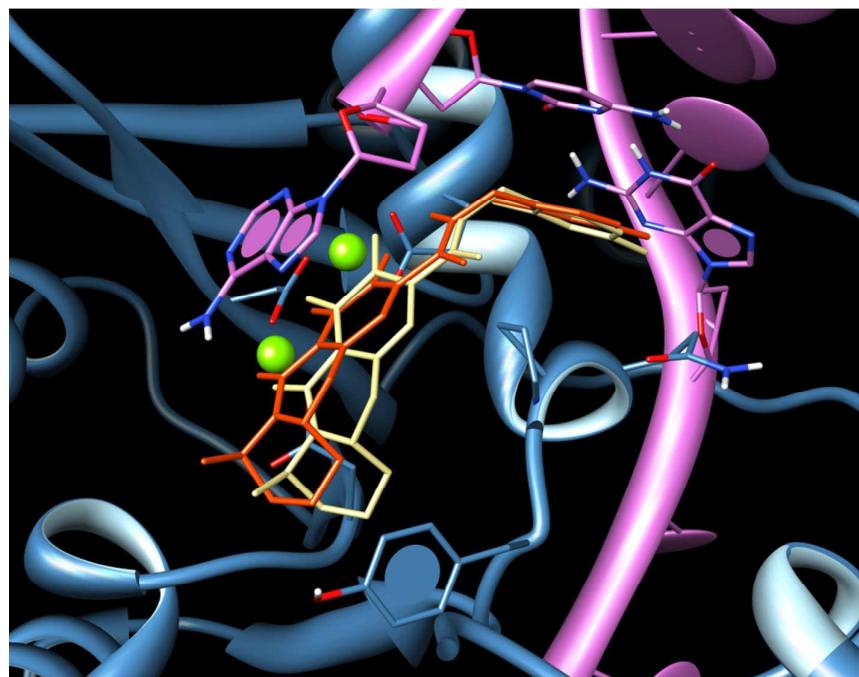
Superimposition of the X-ray position of dolutegravir (orange) and of the best obtained docking pose (cream). IN is depicted in blue, viral DNA in pink and magnesium cations in green.
